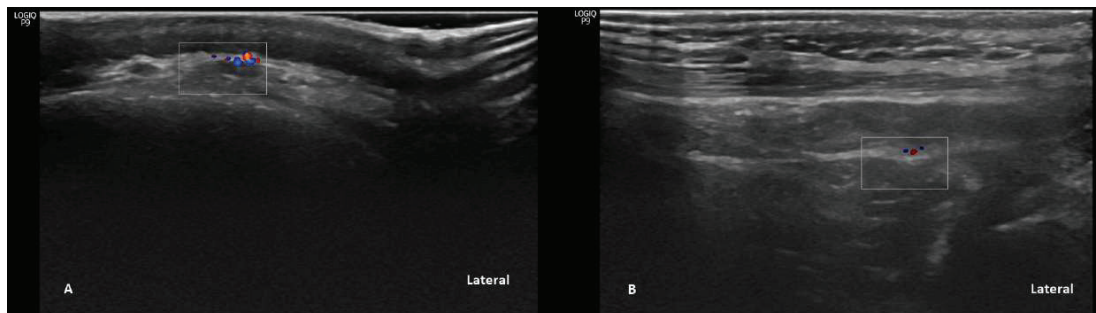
Occipital artery Doppler image at proximal and distal levels
